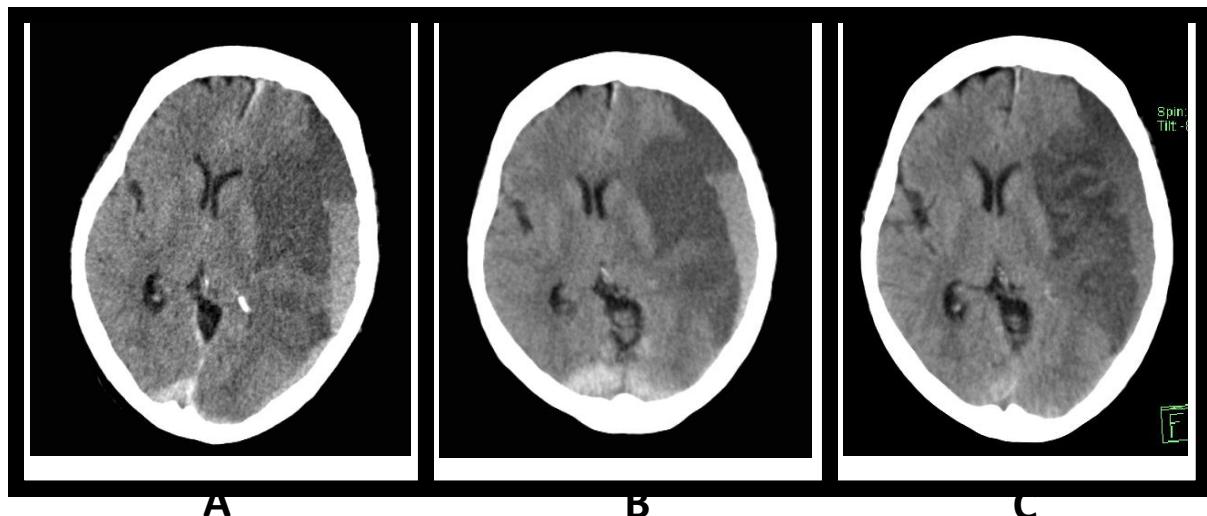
(A) Plain Cranial CT scan done upon admission showing a chronic subdural hematoma in the left frontotemporoparietal area with a maximum thickness of two centimeters with a large area of ill-defined hypodensity in the left hemisphere and a significant midline shift ~1 cm and diffuse cerebral edema; (B) Plain Cranial CT scan done three days after admission showed no progression of the CSDH and CES, no hemorrhagic conversion and a minimal decrease in the midline shift; (C) Cranial CT scan done after 14 days of hospitalization revealed some areas of reperfusion with a further decrease in the midline shift ~0.5 cm.
